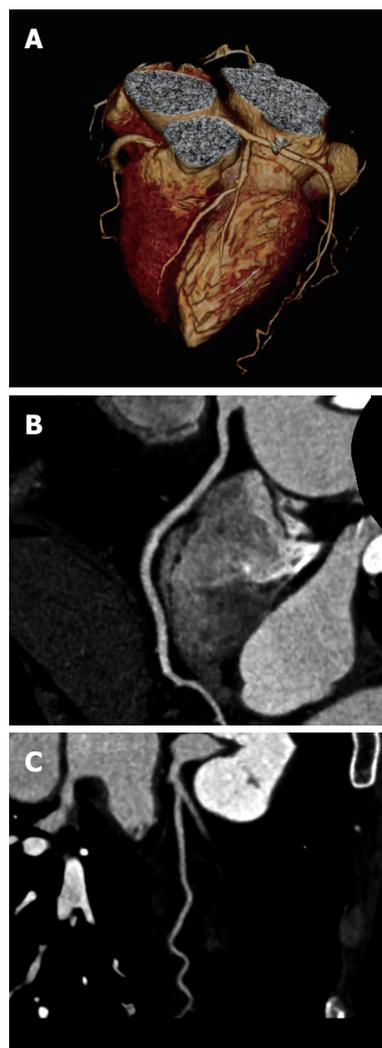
Three-dimensional volume rendering image acquired with 64-slice coronary computed tomography angiography demonstrates right and left coronary arteries without lumen stenosis.
